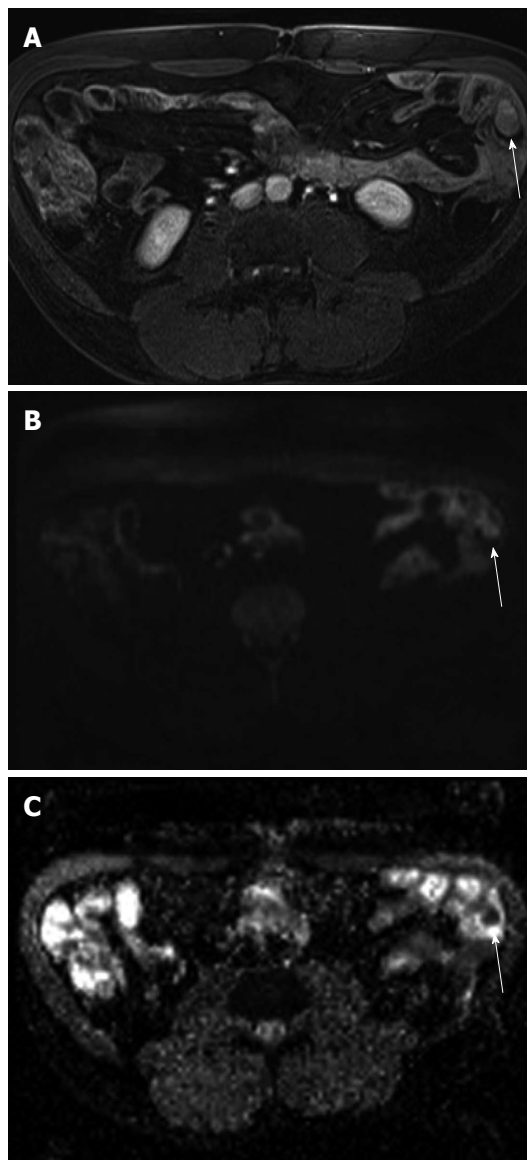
Polyp 3 in a 54-year-old male with known peutz-Jeghers syndrome. A: Axial fat-saturated Vibe gadolinium-enhanced T1-weighted shows a small-bowel slightly enhancing jejunal polyp (arrow); B, C: The corresponding images on a high b ($b = 800$) value diffusion-weighted MRI shows a high-signal intensity polypoid lesion inside a jejunal small-bowel loop with a low ADC value compared with the surrounding small-bowel lumen ($ADC = 1440 \text{ mm}^2/\text{s}$) (arrow).
